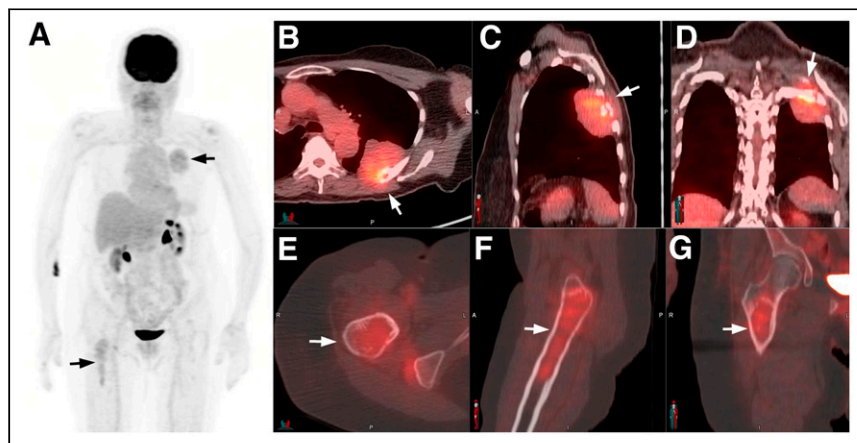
Anterior PET maximum-intensity-projection image shows the borderline hypermetabolic lesions of left thorax and right proximal femur (A, arrows). (B–G) Corresponding axial, sagittal, and coronal fused PET/CT of the mass of lung and chest wall (B–D, arrows) and of proximal right femur (E–G, bone window, arrows).
